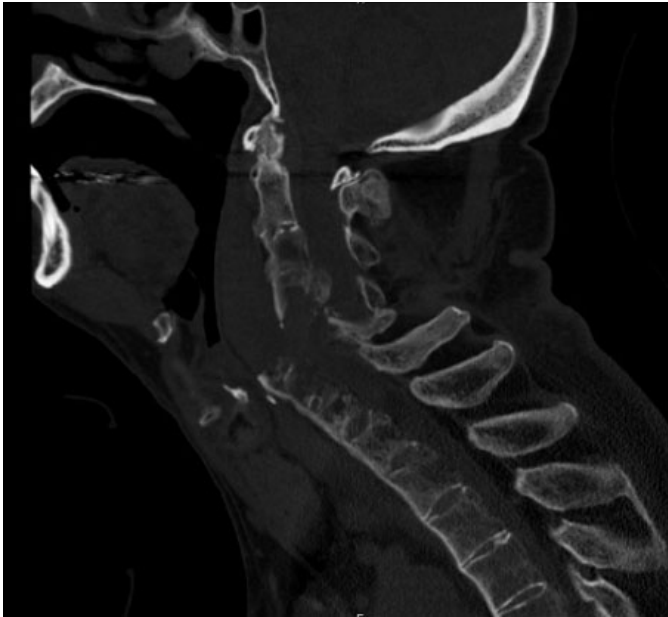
Pre-operative computed tomography of the cervical spine demonstrating the subaxial cervical fracture-dislocation with the caudal fragment steeply imbedded into the parapharyngeal soft tissues. Note the decreased bone mineral density of the spinal column and bridging ossification of the anterior longitudinal ligament classic of ankylosing spondylitis.
